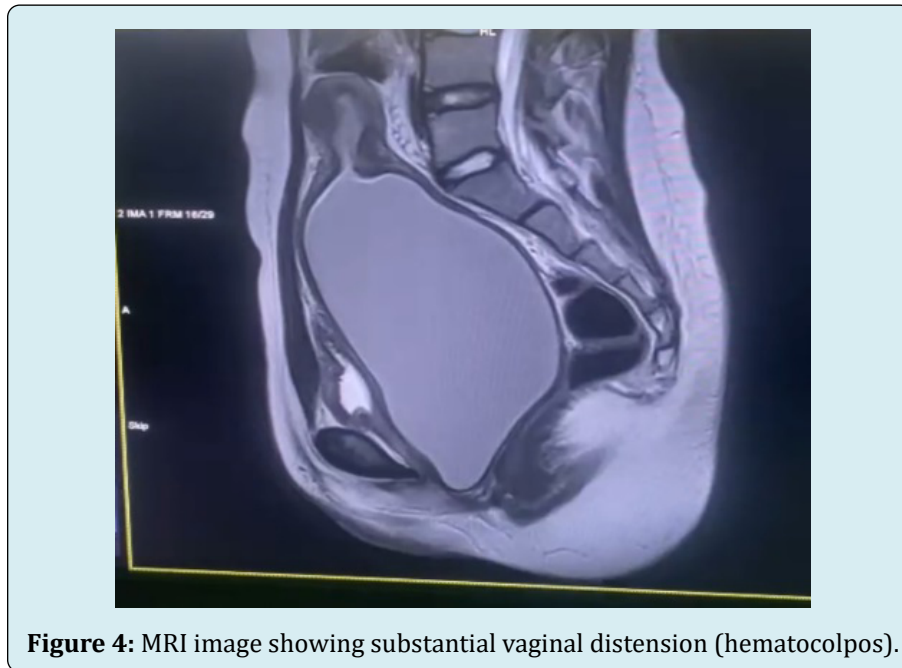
MRI image showing substantial vaginal distension (hematocolpos).
